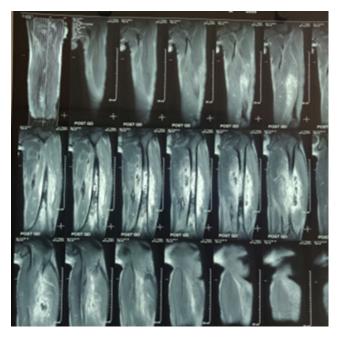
MRI showing multiple pockets of abscess in the bone and muscle plane
